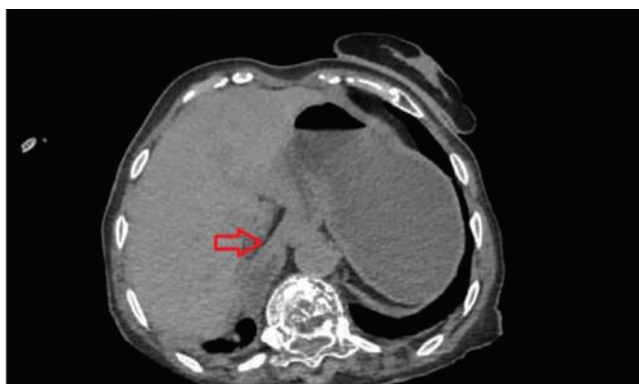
Axial CT scan showing herniation and rotation of the stomach into the mediastinum (red arrow).
